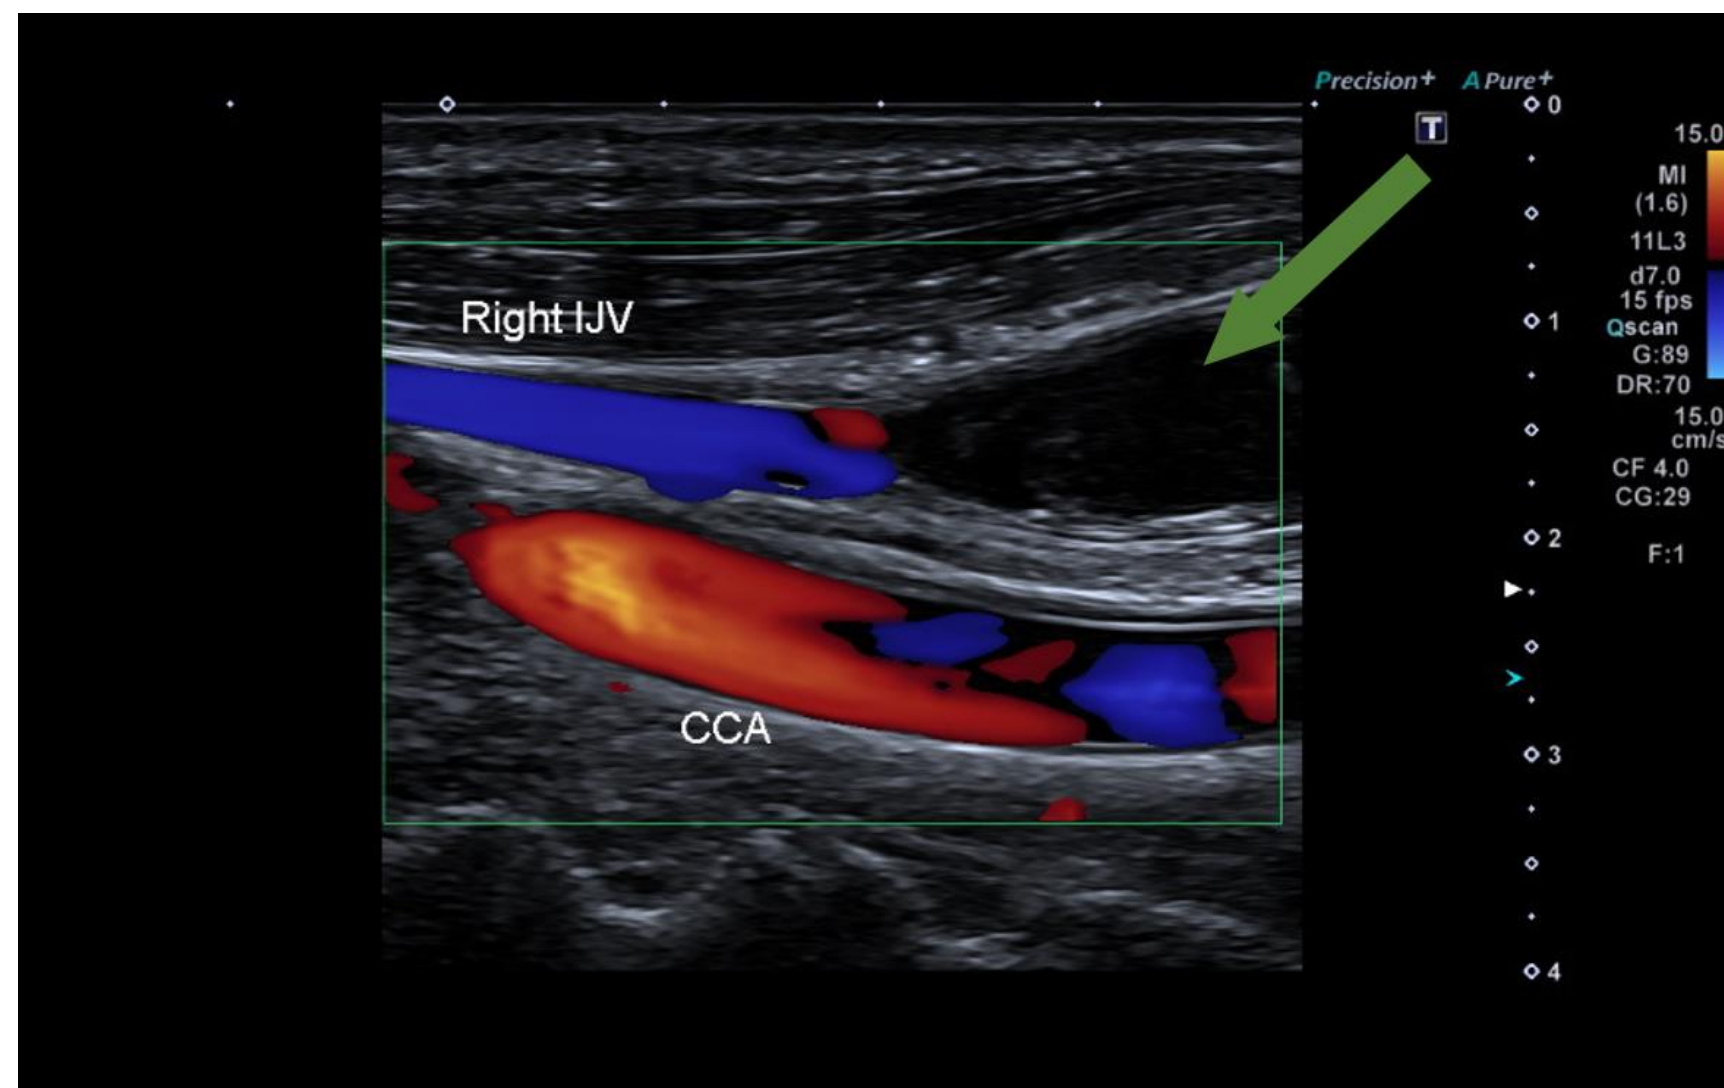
A Duplex (B-mode and colour Doppler) longitudinal image of the right common carotid artery (CCA) and internal jugular vein as labelled. The green arrow highlights the area of occlusive echogenic thrombus and therefore no blood flow within (Hospital "X", 2023).
